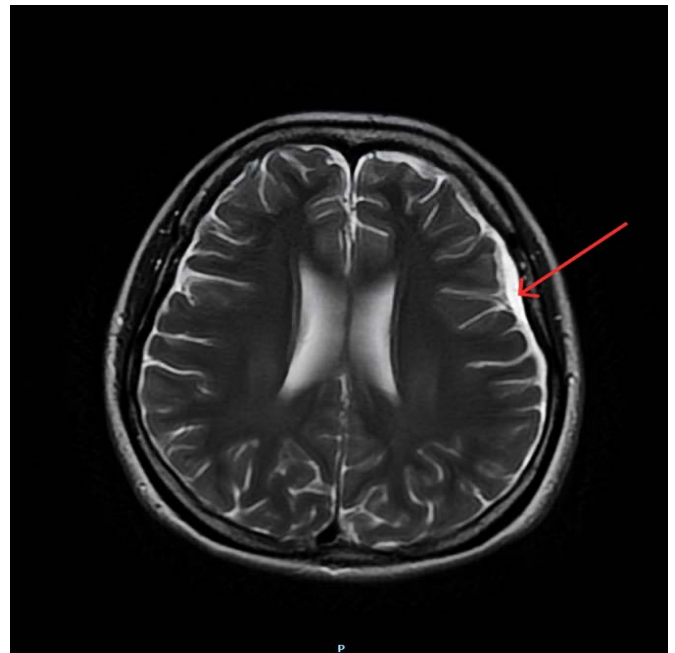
MRI on postoperative day nine revealed a 5 mm subdural hematoma with an associated effusion in the left frontoparietal region (red arrow).
